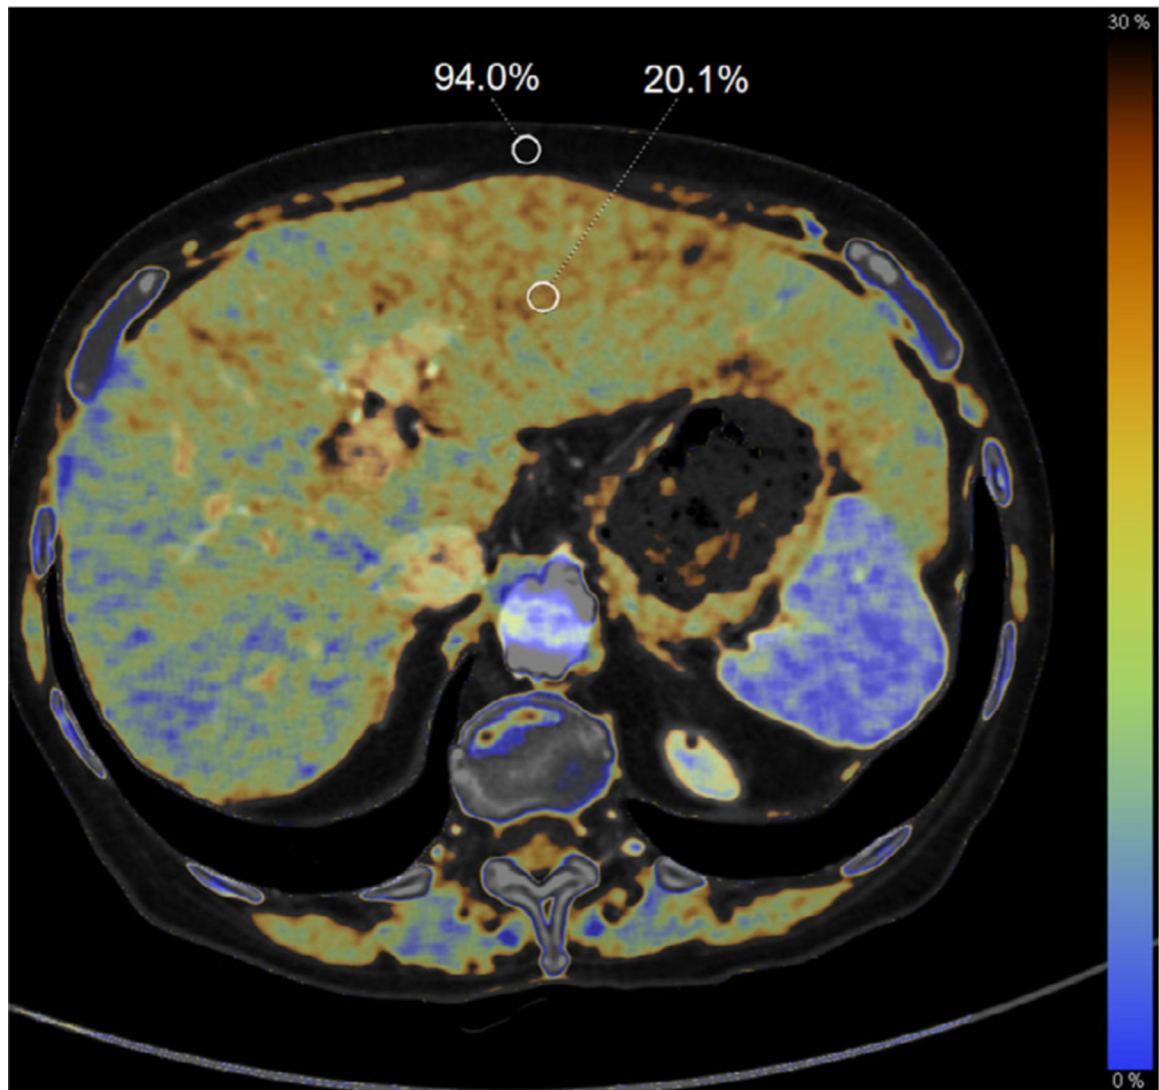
Fatty infiltration of the liver demonstrated on a dual-energy computed tomography fat map in a 75-yr-old woman with pancreatic adenocarcinoma following chemotherapy. The calculated fat fraction for regions of interest in the liver (20.1%) and subcutaneous fat (94.0%) are shown as a percent volume.
